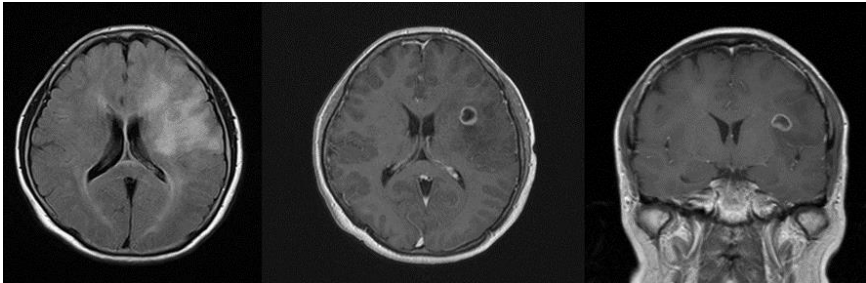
Head MRI showing extensive vasogenic edema. Contrast-enhanced MRI indicated a ring-enhanced tumor mass in the white matter under the speech and primary motor areas.
